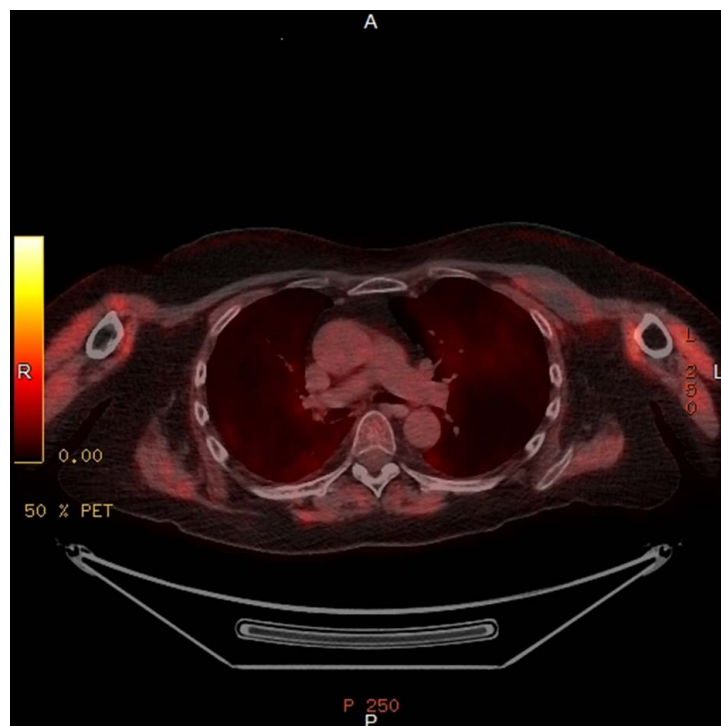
Fused axial image through the upper thorax from the PET CT demonstrates an area of photopaenia in the left pectoralis major muscle corresponding to the intramuscular haematoma, showing significant reduction in size compared to the previous CT. Diffuse increased tracer uptake in the skeletal musculature consistent with dermatomyositis.
